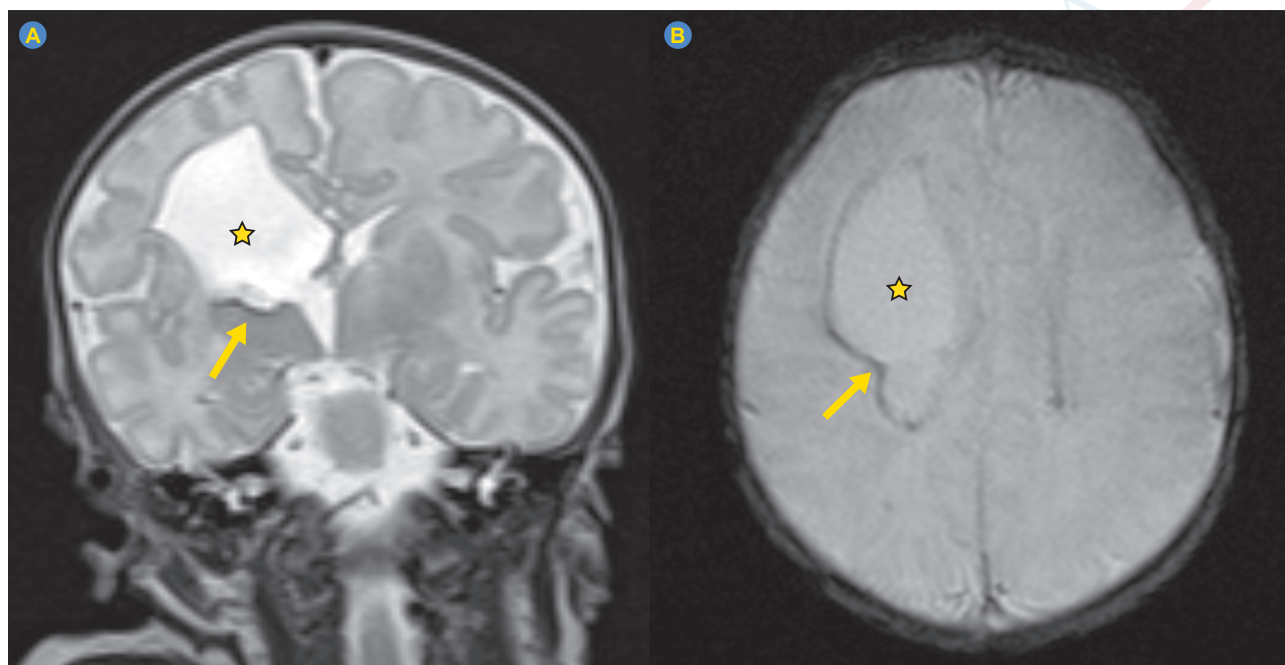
Brain MRI. Coronal T2 weighted-image (WI) (A) and axial T2*-WI (B), depicting right frontal porencephalic cavity (star) with peripheral hemorrhagic residues (arrow)
